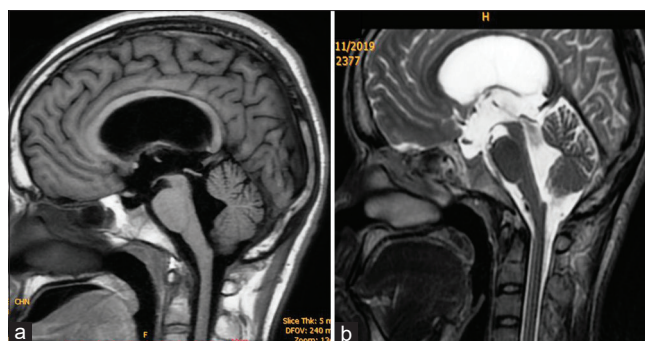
Sagittal (a) T1-weighted and Sagittal (b) T2-weighted postoperative magnetic resonance images showing complete disappearance of Chiari malformation type I and Syringomyelia with a resolution of hydrocephalus
